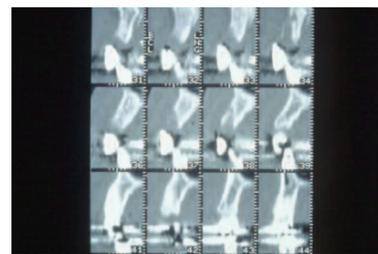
CT-Scan of a patient 28 days after extraction of 4 prominent roots: Thin buccal bone plates resorb and are hardly visible anymore.
